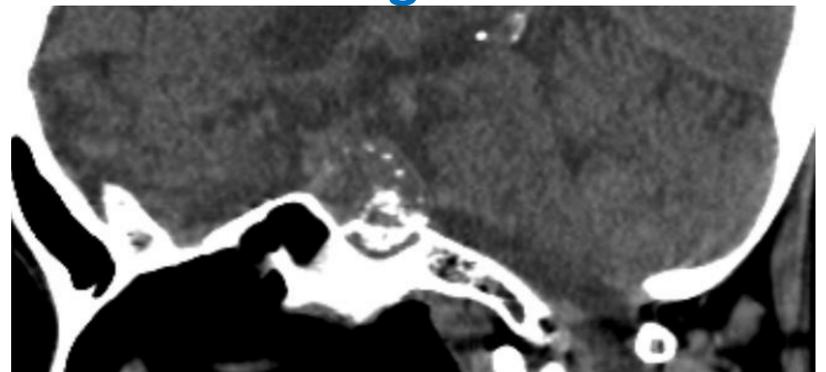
Sagittal noncontrast CT demonstrates key findings of intralesional coarse, punctate, and curvilinear calcifications which represent sequestra from bone destruction rather than dystrophic calcifications of the tumor itself.
